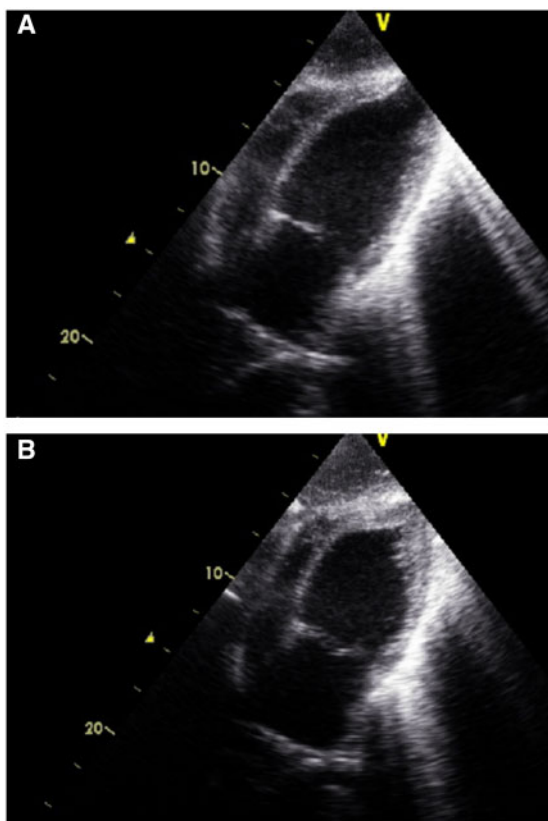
Admission echocardiography showing subcostal view of the left ventricle at end-diastole (A), and end-systole (B).
